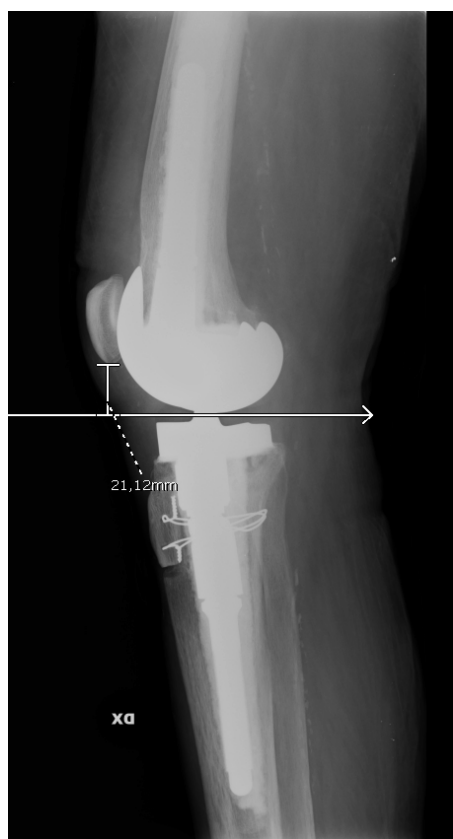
First month after surgery. Height of patella reduced and radiographic signs of consolidation.
